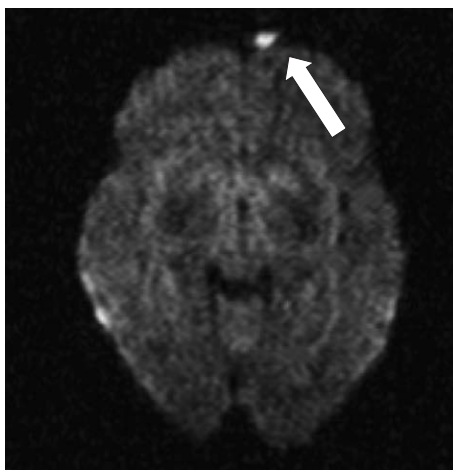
Diffusion-weighted MR imaging obtained on April 1 showed a high intensity area in the left frontal tip (white arrow).
